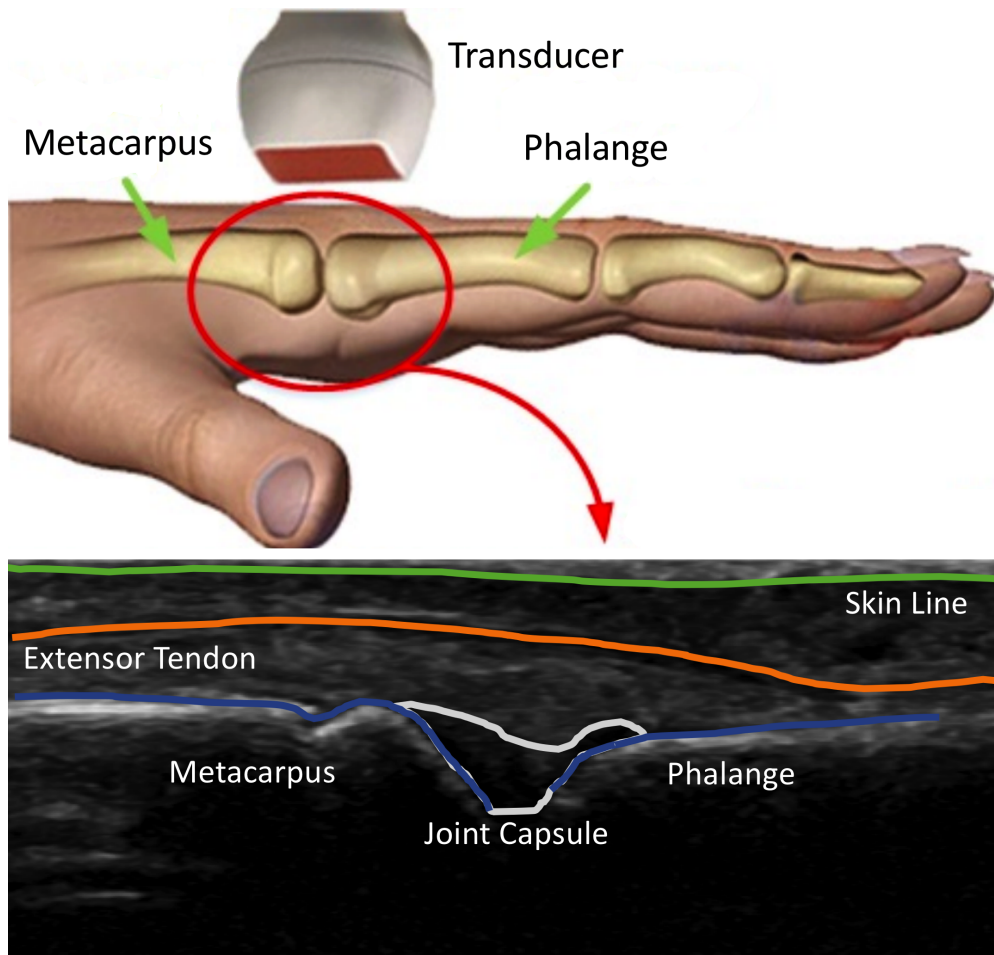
Representation of the second MCPJ ultrasound image acquisition.
